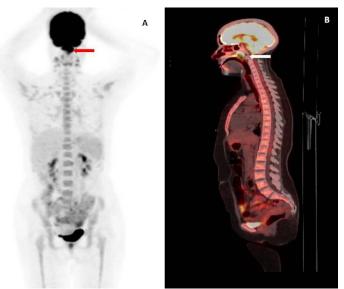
18-FDG PET scan of treatment evaluation after two treatments (MIP on the left and sagittal section on the right) showing the persistence with a clear decrease of the previously described hypermetabolic foci in the cavum tumor process and cervical lymph node involvement.
